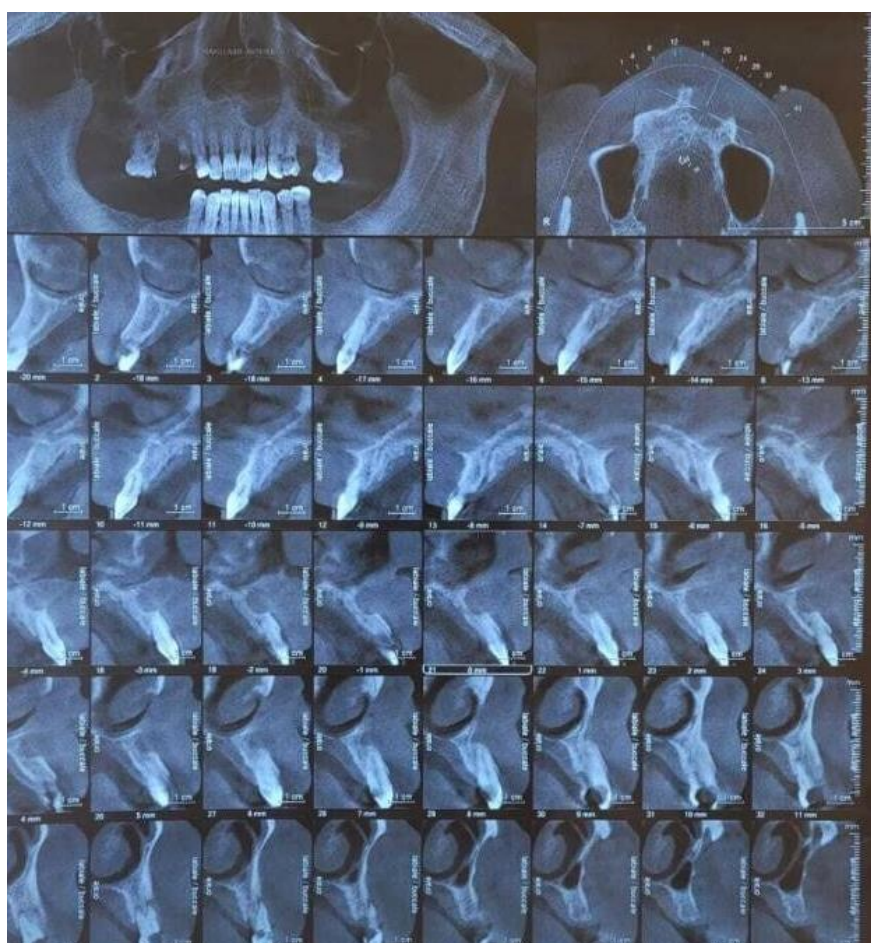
CBCT cross-sectional images demonstrating a well-circumscribed radiolucent lesion in the anterior maxilla, adjacent to teeth 21 and 22 producing a marked cortical depression
